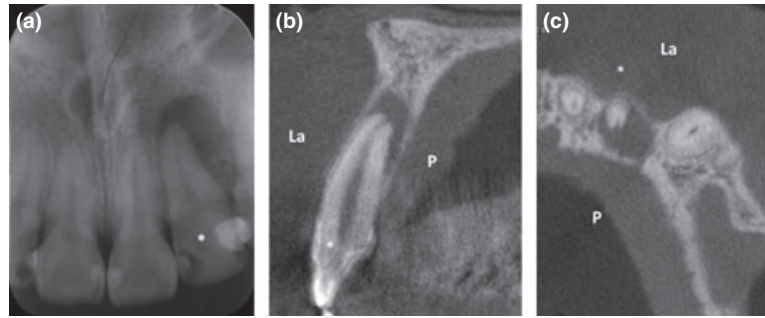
Type II: A periapical bone defect was observed on the labial side of the bone around the apex of the maxillary left lateral incisor (*). (a) Periapical radiograph. (b) Labio-palatal slice image of the CBCT (3DX). (c) Horizontal slice image of the CBCT (3DX). La: labial side. P: palatal side.
